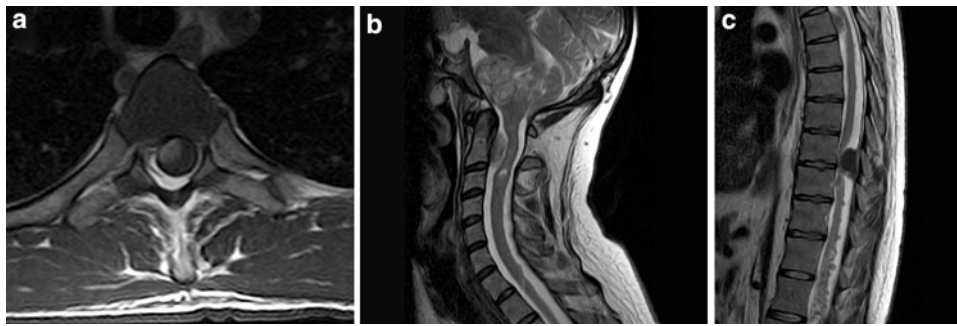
MRI showing aspects of spinal meningiomas in NF2 patients. a axial T1-weighted sequence with Gadolinium enhancement showing a right anterior lateral thoracic meningioma compressing the spinal cord. b, c sagittal T2-weighted sequence (b) anterior C2
